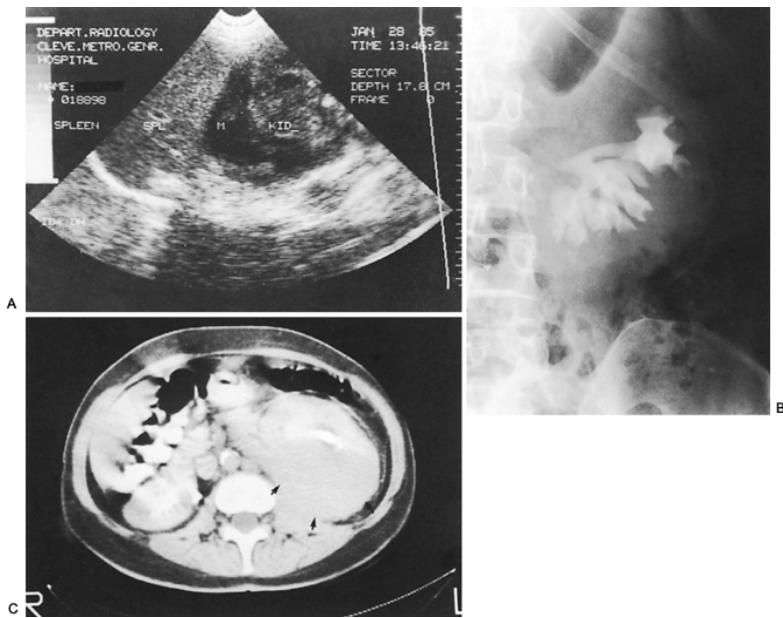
27. A: Longitudinal scan of retroperitoneum demonstrating left perirenal mass. KID, kidney; M, mass; SPL, spleen. Surgical exploration revealed lymphoma. Intravenous urogram (B) and computed tomography (C) from same patient.
